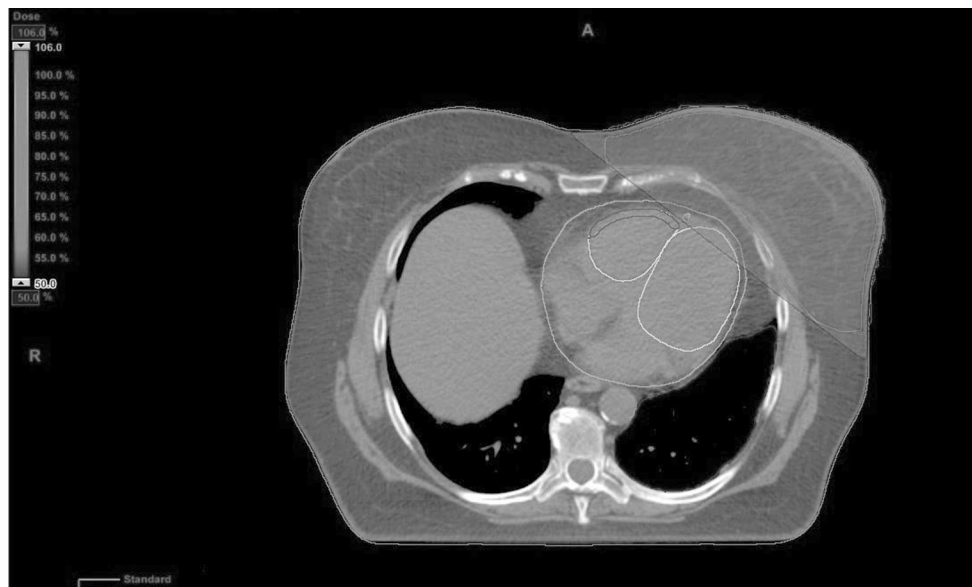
A horizontal segment of the planning CT. Tangential photon fields are used in the treatment of the left breast. Fifty per cent of the total radiation dose is shown as radiation field. The cardiac structures are also contoured
